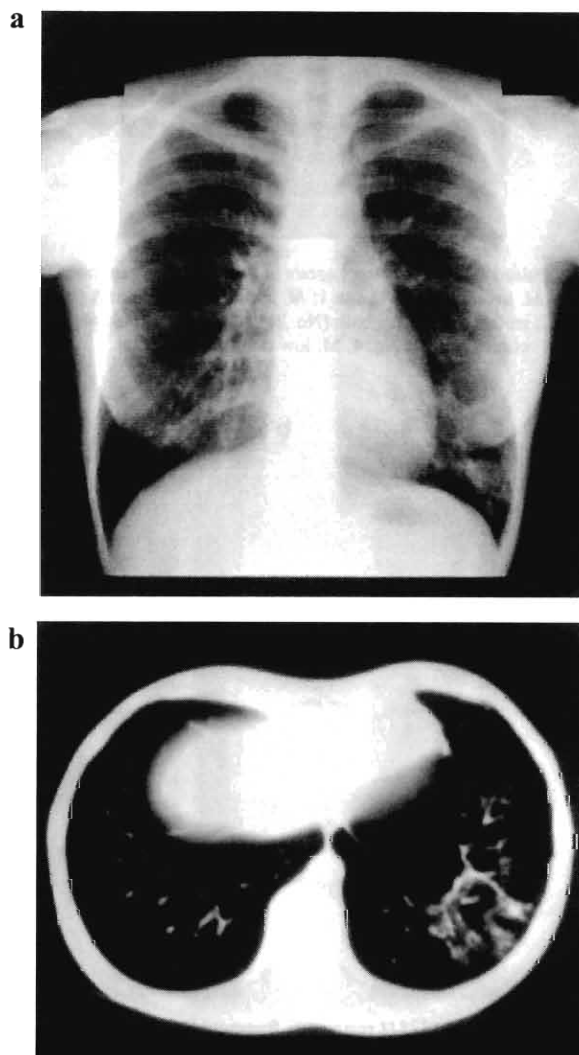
Chest radiograph (a) and chest CT scan (b) before therapy.
